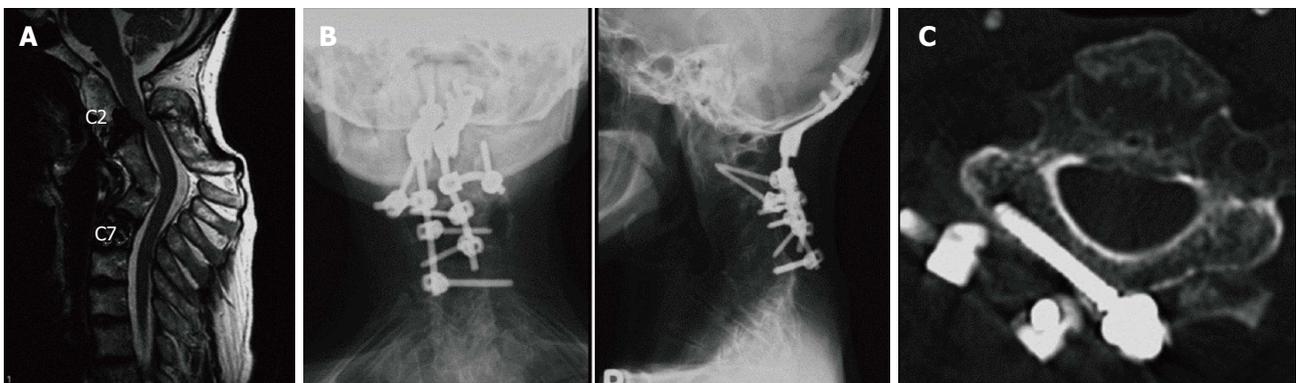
Case 3. A: A magnetic resonance imaging scan image showing severe cervical kyphosis with junctional canal stenosis at the C2-3 levels; B: Roentgenograms showing posterior arthrodesis performed using occipital plates, C2 pedicle screws, and laminar screws at the C3-C6 levels; C: A computed tomography image showing an appropriately inserted C3 laminar screw.
